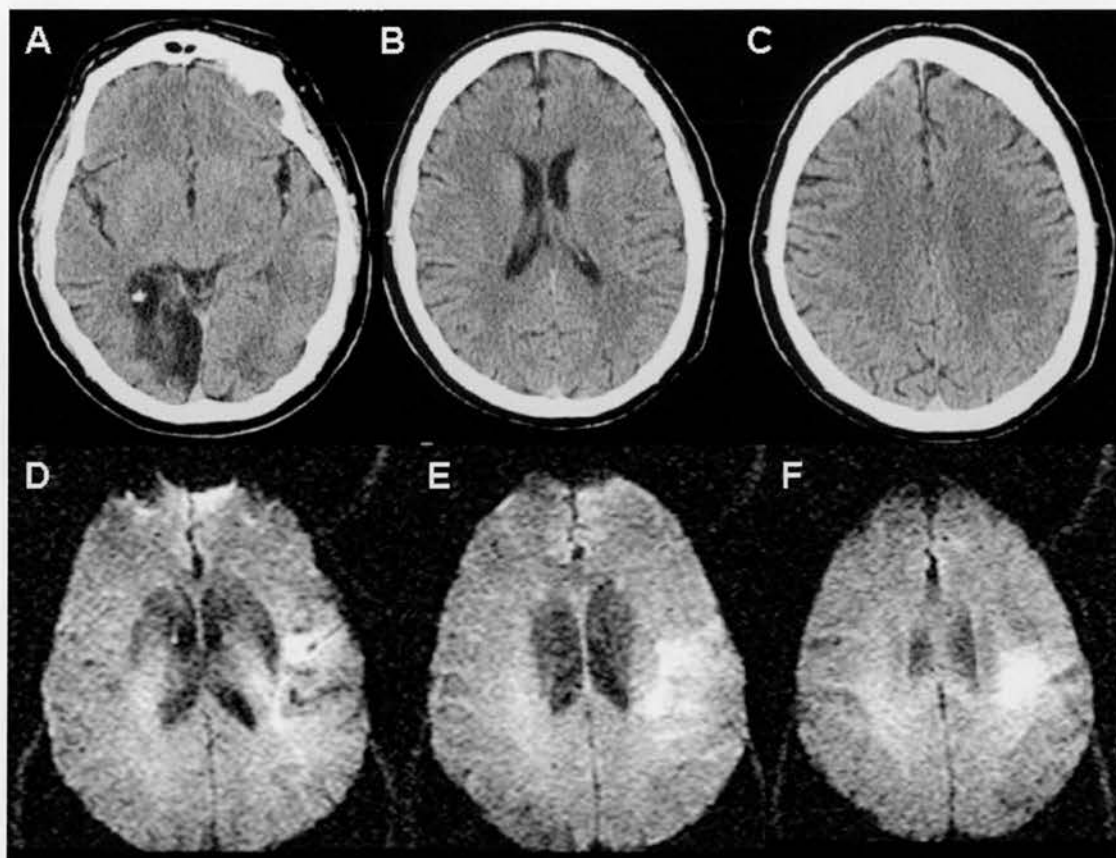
Overcalling in Real time. A, B and C show the representative cuts from a CT scan performed at 3 hours and 8 minutes after symptom onset on an acute stroke patient with right hemiparesis and aphasia (NIHSS 16). The treating physician rated the scan as having an ASPECTS of 4 with regions: Insula, M2, M3, M4, M5 and M6 rated as abnormal. Later expert review of the scan rated the scan as having an ASPECTS of 7 with regions: Insula, M2, and M3 rated as abnormal (MCA dot sign seen on cut A). C, D and E show the diffusion weighted MR performed 4 hours and 40 minutes after symptom onset. An evolving infarct is seen in ASPECTS regions; Insula, M2, M3, and M5 (total score 6).
